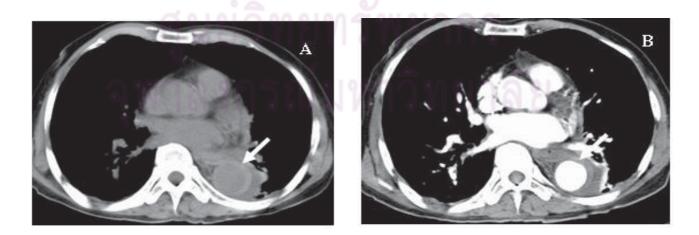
Imaging of intramural hematoma (IMH). A: Unenhanced CT scan depicts crescent-shaped area with high attenuation (*arrow*) extending along wall of descending aorta. Periaortic fluid is visible. B: CTA shows no enhancement of crescent-shaped areas (*arrow*). IMH is less apparent, compared to the unenhanced CT scan in A.
